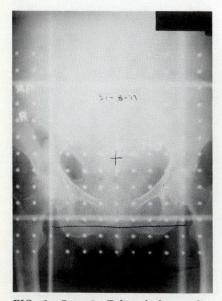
Case 1. Taken before radiotherapy, x-ray with marking grid shows acetabular walls inside radiation field. Iliac bone-graft donor sites are outside field.
